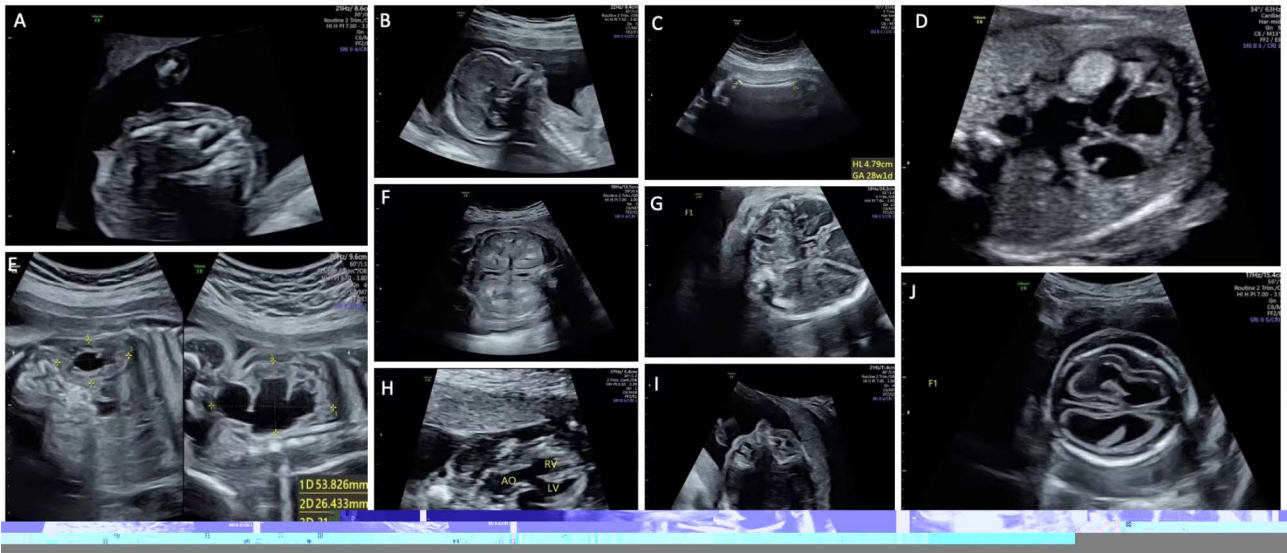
Ultrasound images of foetal abnormalities. (A) 17w cleft lip and palate; (B) 18w small mandibular deformity; (C) 36w^{4d} long bones short for 8 weeks; (D) 27w^{5d} rhabdomyosarcoma (multiple); (E) 26w unilateral hydronephrosis; (F) 35w rhabdomyosarcoma; (G) 32-35w Blake's cyst (this image shows a normal sized cerebellar earthworm); (H) 22w Preeclampsic heart disease (Act IV) with generalised oedema (thickening of the skin, pericardial effusion), intravenous catheter, A-wave reversal, this case is a recipient in TAPS; (I) 28-30w Congenital cataract with permanent vitreous hyperplasia, this image shows intra-lens cataract and permanent vitreous hyperplasia; (J) 24w^{+3d} Pleural and abdominal effusion Skin oedema Cerebral oedema Cerebral sulcus gyrus shallowing Cerebral sulcus gyrus widening Fissure widening Enlarged heart (in a recipient of TTTS with heart failure Total body oedema including cerebral oedema)
